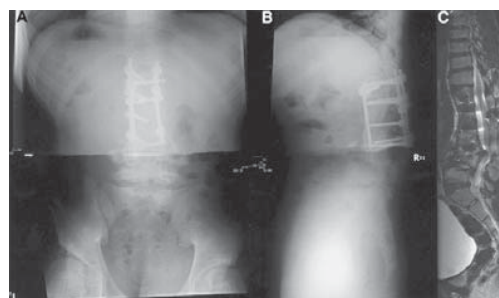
Anteroposterior (A) and lateral (B) plain radiographs of the spine revealed extensive degeneration at L4 and L5 levels, with associated anterior wedging, collapse, and extrusion of bony fragments anteriorly at L4 vertebral body. Posterior vertebral height loss at L5 level was also evident. Consequently, the L3–L5 levels were kyphotic, with increased compensatory lordosis at L5–S1 segment. Sagittal MRI view (C) shows the development of junctional kyphosis and spinal canal compression.
